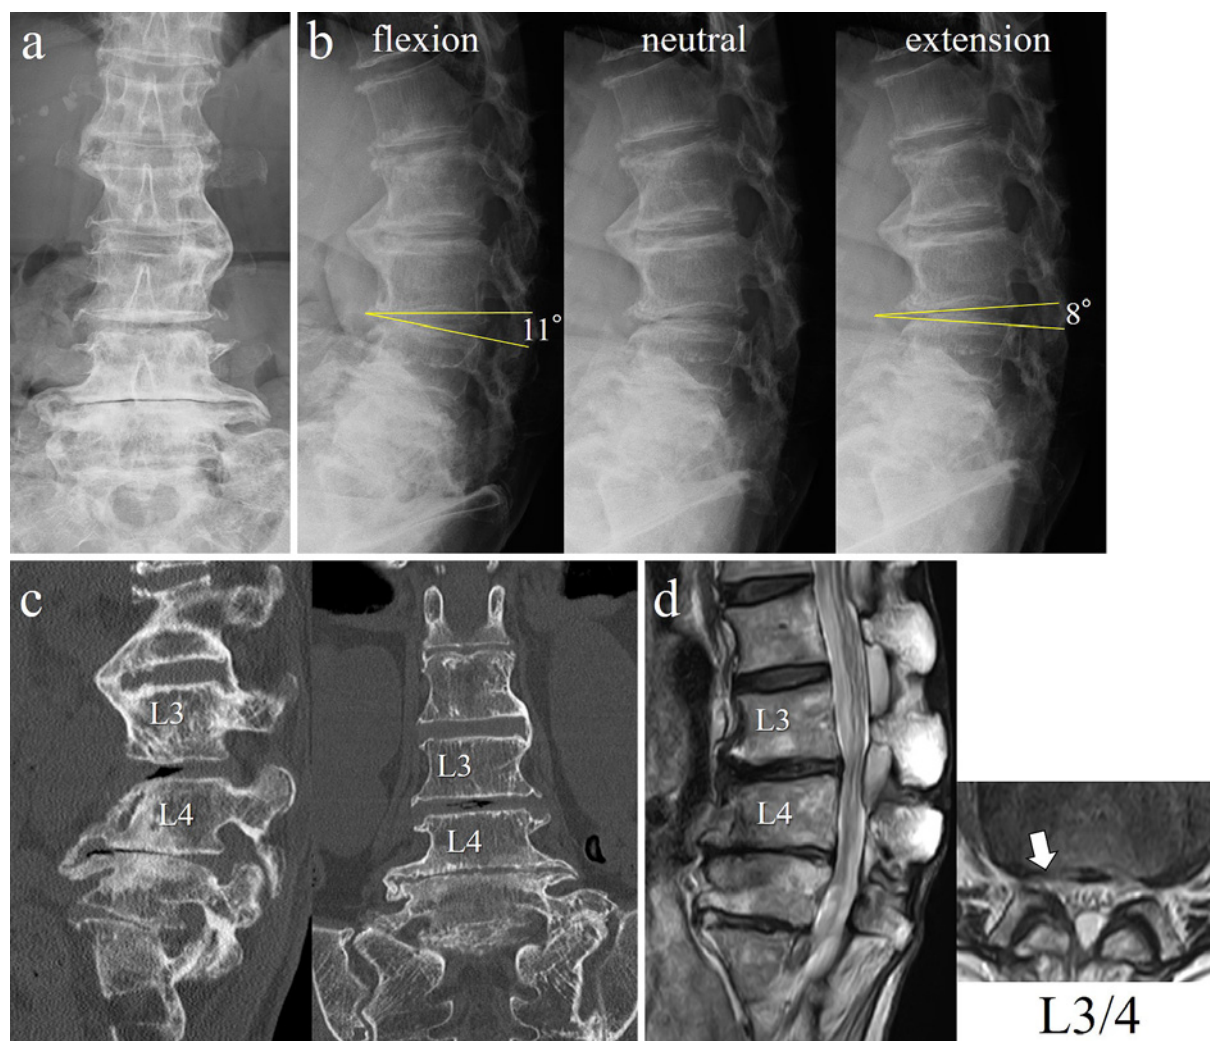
Preoperative plain X-ray images: (a) anteroposterior view and (b) lateral view in flexion, neutral, and extension, with a 3° L3/4 lateral disc mobility between flexion and extension; (c) computed tomography scans showing osseous bridging of the vertebrae from L2 to L3 and from L4 to the sacrum; (d) preoperative sagittal T2-weighted magnetic resonance images, showing lumbar spinal canal stenosis at L3/4, and magnetic resonance imaging in the axial plane, showing lateral recess stenosis on the right side (arrow).
